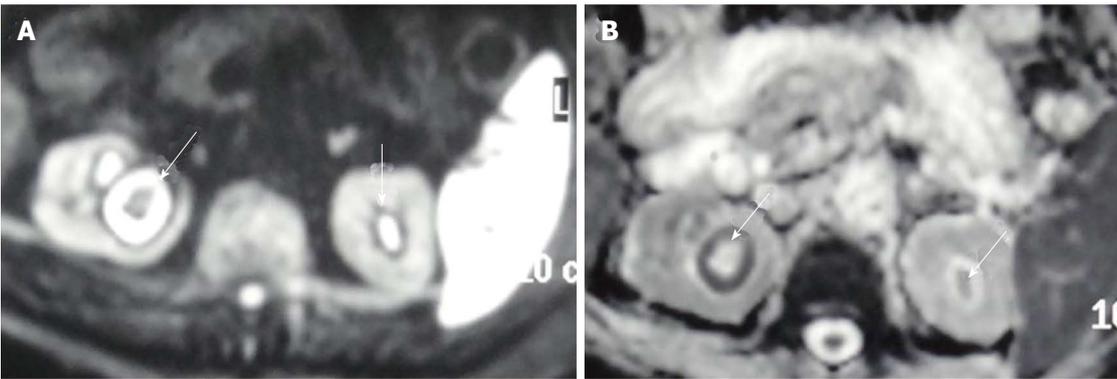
Diffusion weighted magnetic resonance imaging at b = 1000 (A) and corresponding ADC map (B) show hydronephrosis with diffusion restriction suggestive of pyonephrosis (arrows).
